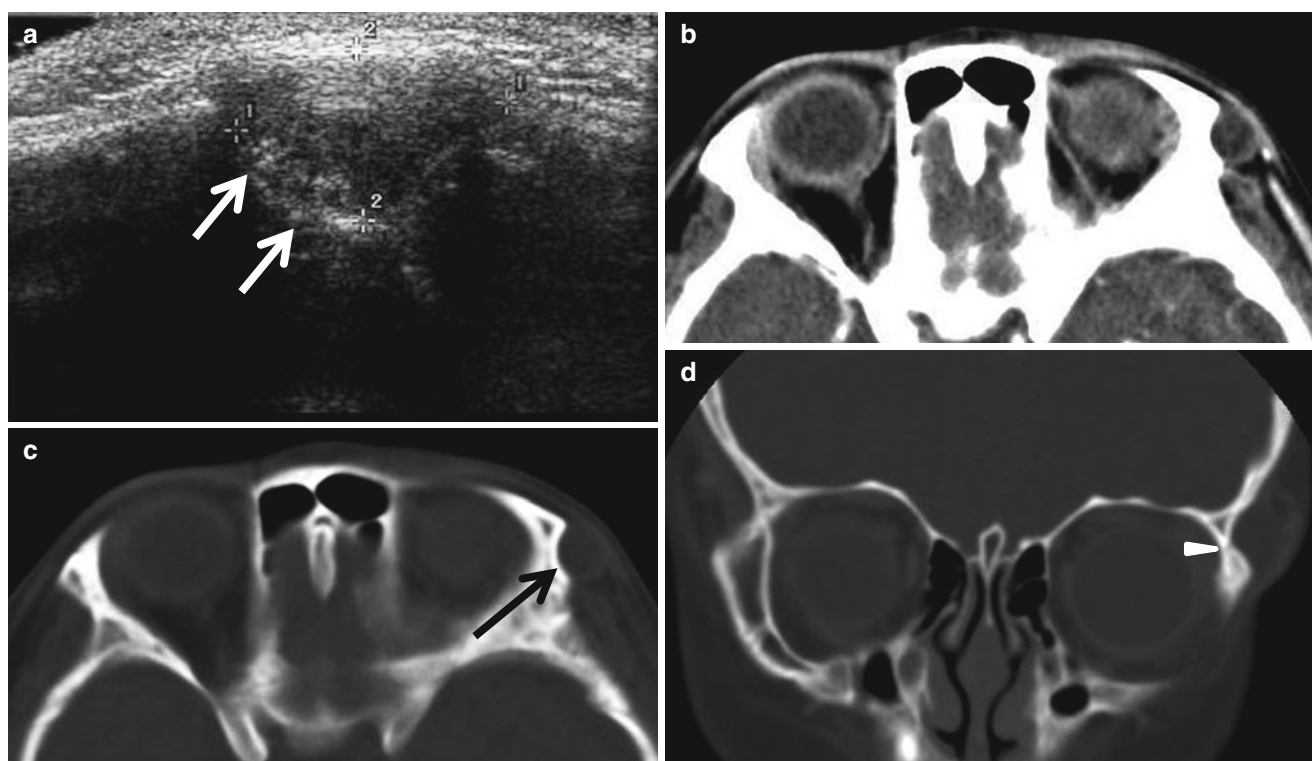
Orbital dermoid cyst in a 5-year-old girl. (a) US shows an oval-shaped nodule with internal echogenic foci in the superolateral wall of the orbit. The underlying bony cortex of the orbital rim produces the appearance of a fossa (arrows). (b) Contrast-enhanced axial CT
